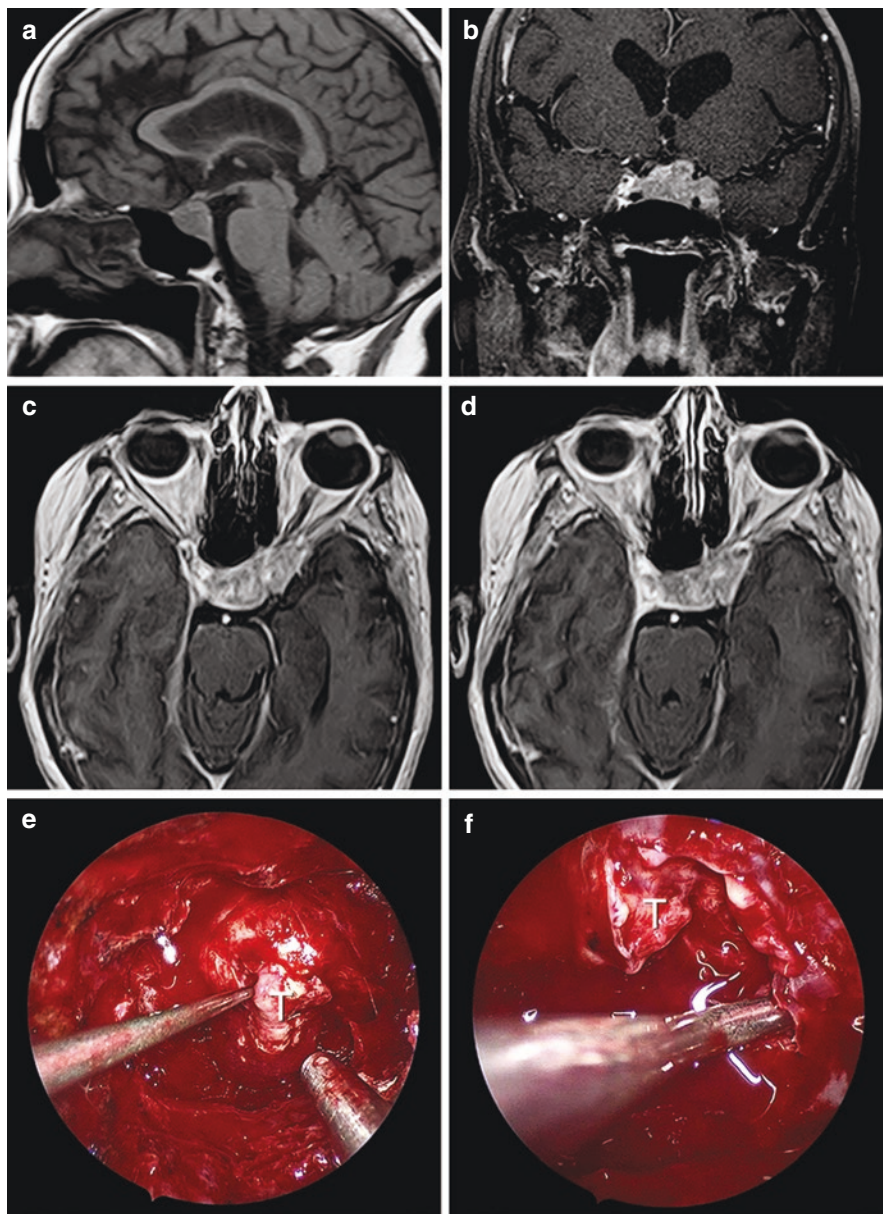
Crooke's cell adenoma. Preoperative MR images (a–d) and intraoperative views during endoscopic endonasal transsphenoidal resection of the tumor (T), (e, f)
